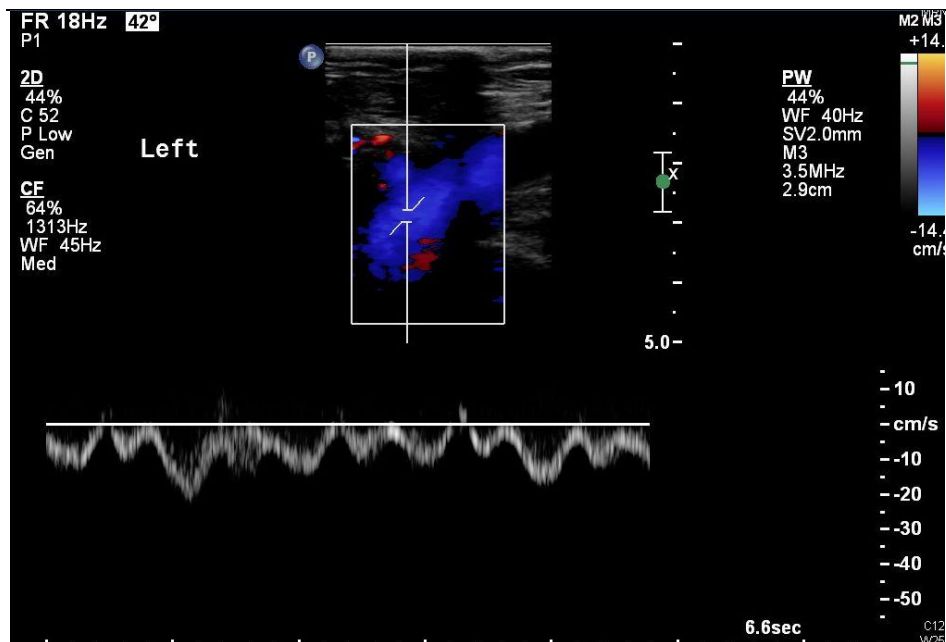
Normal Doppler spectral trace of the distal external iliac vein showing flow changes due to proximal respiration and R heart pressure changes.
